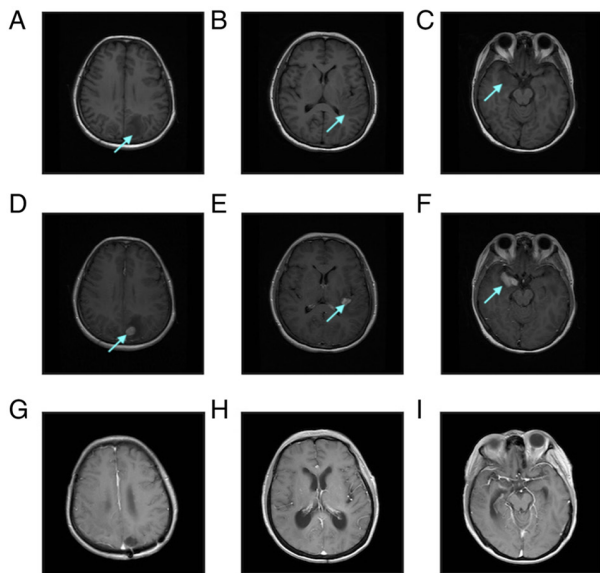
Pre-treatment and post-treatment MRI examinations of the patient. (A-C) Pre-contrast axial T1-weighted imaging revealed multiple patch-shaped hypo-intense shadows in both the parietal and temporal lobes, with blurred boundaries. (D-F) Post-contrast axial T1-weighted MRI showed multiple intense nodular mass enhancement shadows in both the parietal and temporal lobes. (G-I) After treatment with the Bruton tyrosine kinase inhibitor combined with the programmed cell death protein 1 monoclonal antibody regimen, post-contrast axial T1-weighted MRI showed the tumor lesion had disappeared and the surrounding patchy edema zone was no longer enhanced. The arrows show the tumor masses. MRI, magnetic resonance imaging.
